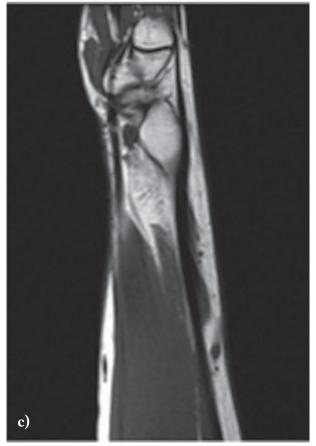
(a) FSE T2-w Fat-Sat axial (a) and coronal (b), T1-weighted sagittal sagittal (c): well-definited ovoid subcutaneous mass with an intermediate signal intensity (similar to that of muscle) on T1-weighted images and an intermediate-high signal intensity with a typical fascicular pattern on FSE T2-weighted images
